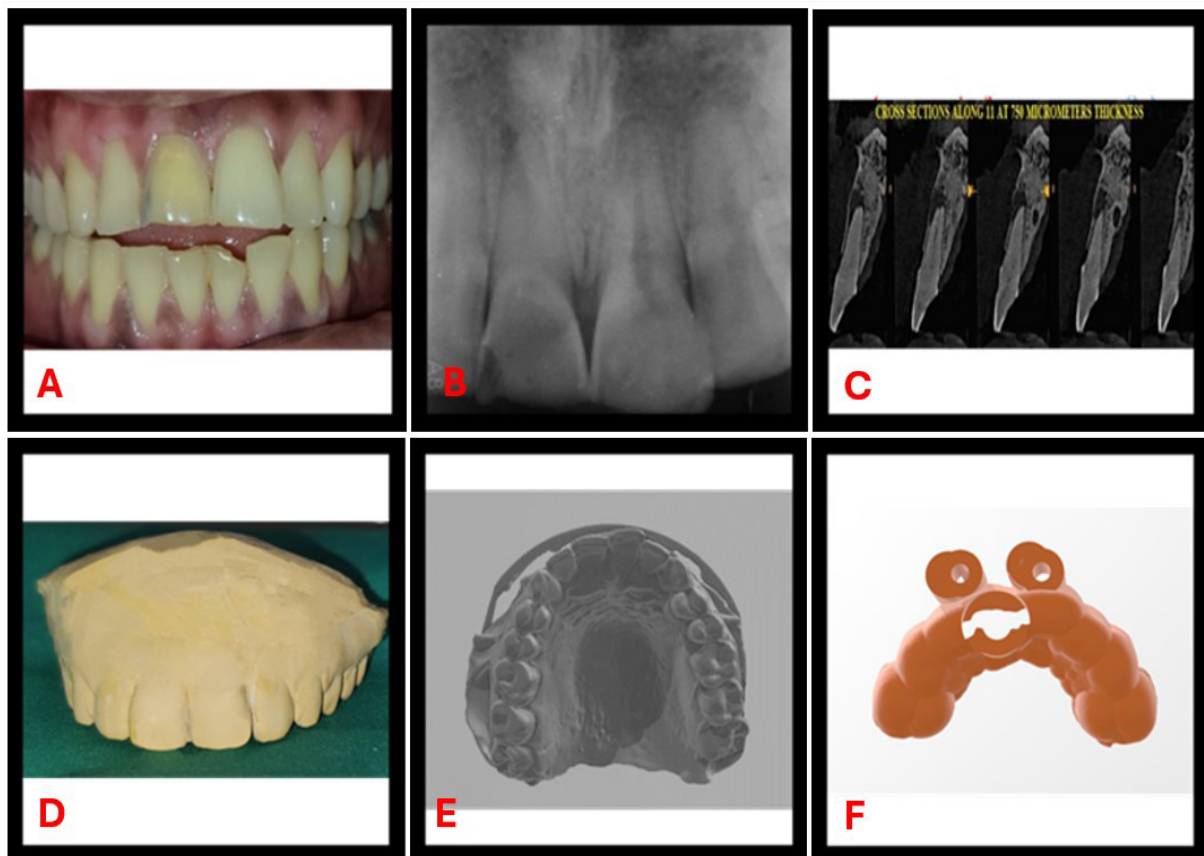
A) Pre-operative photograph showing discoloured tooth in relation to 11; B) Pre-operative radiograph showing calcified canal in relation to 11; C) CBCT image showing calcified canal; D) Diagnostic cast; E) STL file of the diagnostic cast; F) Customized guide
